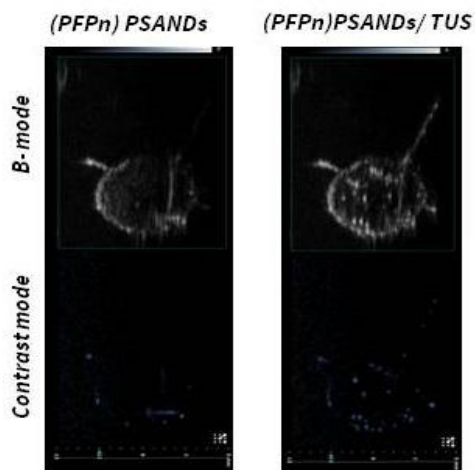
In vitro* ultrasound imaging of PSANDs before and after activation with TUS. (A). US imaging experimental set up. (B). Ultrasonography image of (PFH) PSANDs after activation by TUS with a frequency of 1 MHz and intensity of 5 W/cm<sup>2</sup> for 10 seconds. (C). The effects of TUS frequency and intensity on phase shift induction in (PFH) PSANDs. (D). Ultrasonography images of (PFPn) PSANDs after activation by TUS with a frequency of 1 MHz and intensity of 2 W/cm<sup>2</sup> for 10 s.
